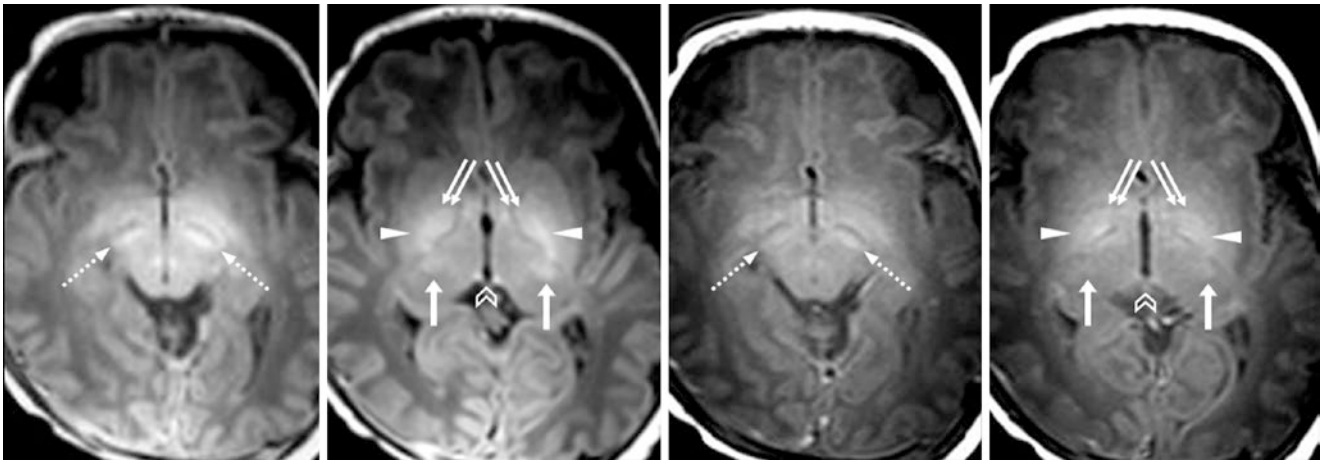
A 3-day-old term neonate with a seizure had a normal 3T MRI, which included spoiled GE T1WIs (*left two images*) and SE T1WIs (*right two images*). Note the bright signal of the GP (*double arrows*), PP (*arrowheads*), VLT (*arrows*), and subthalamic nuclei
